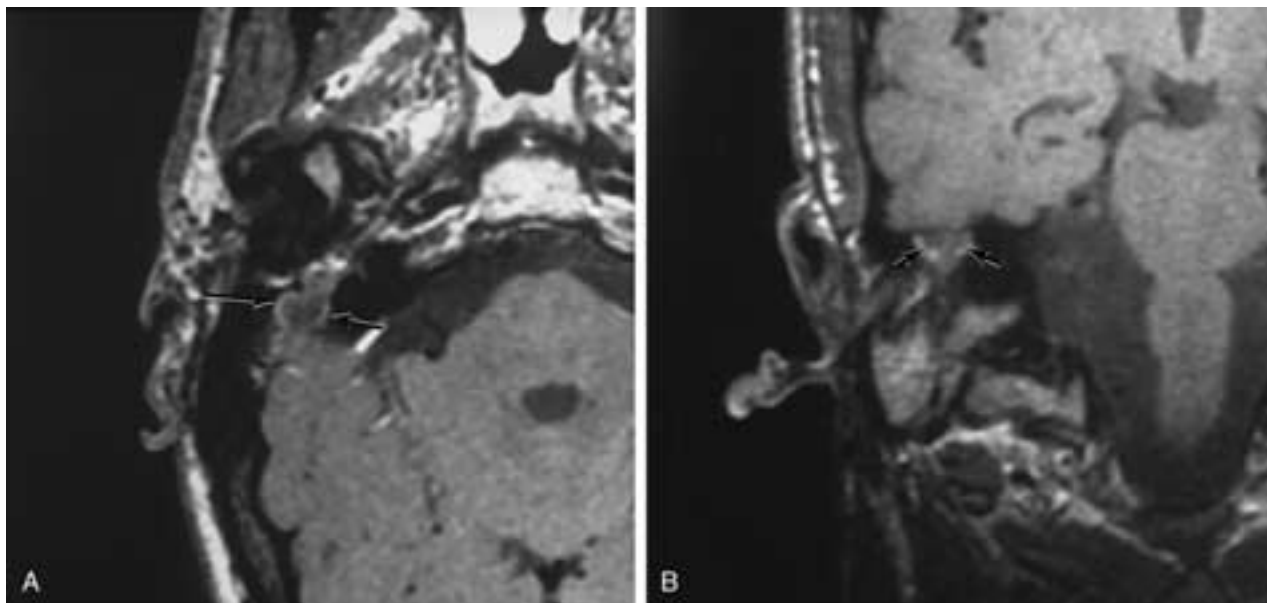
Cholesteatoma—granulation tissue. A and B, Axial and coronal contrast-enhanced, T1-weighted image demonstrates enhancing granulation tissue (*arrows*) surrounding a nonenhancing cholesteatoma.
